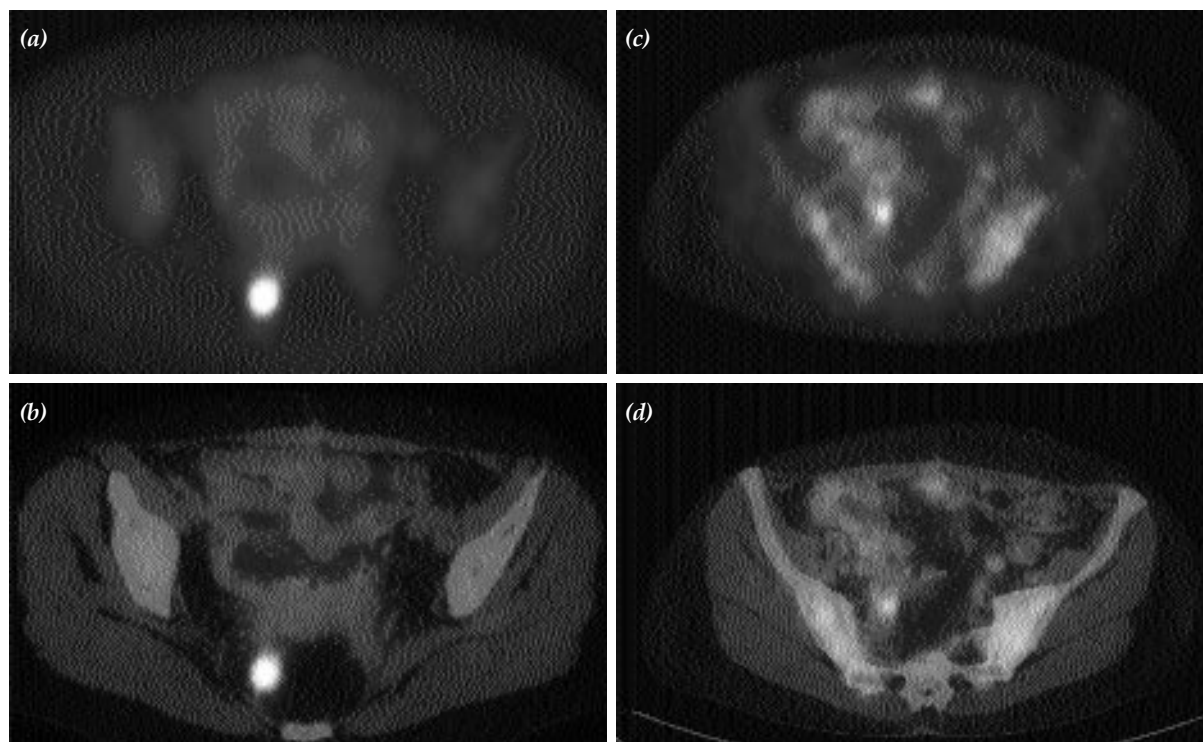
(a) Colorectal cancer, elevated CEA. A "hot" lesion in the pelvic area. (b) PET-CT, correct localization of the lesion by CT. (c) Another soft tissue lesion, PET with increased FDG uptake on the right side. (d) Correct localization of the PET lesion by the fused image.
